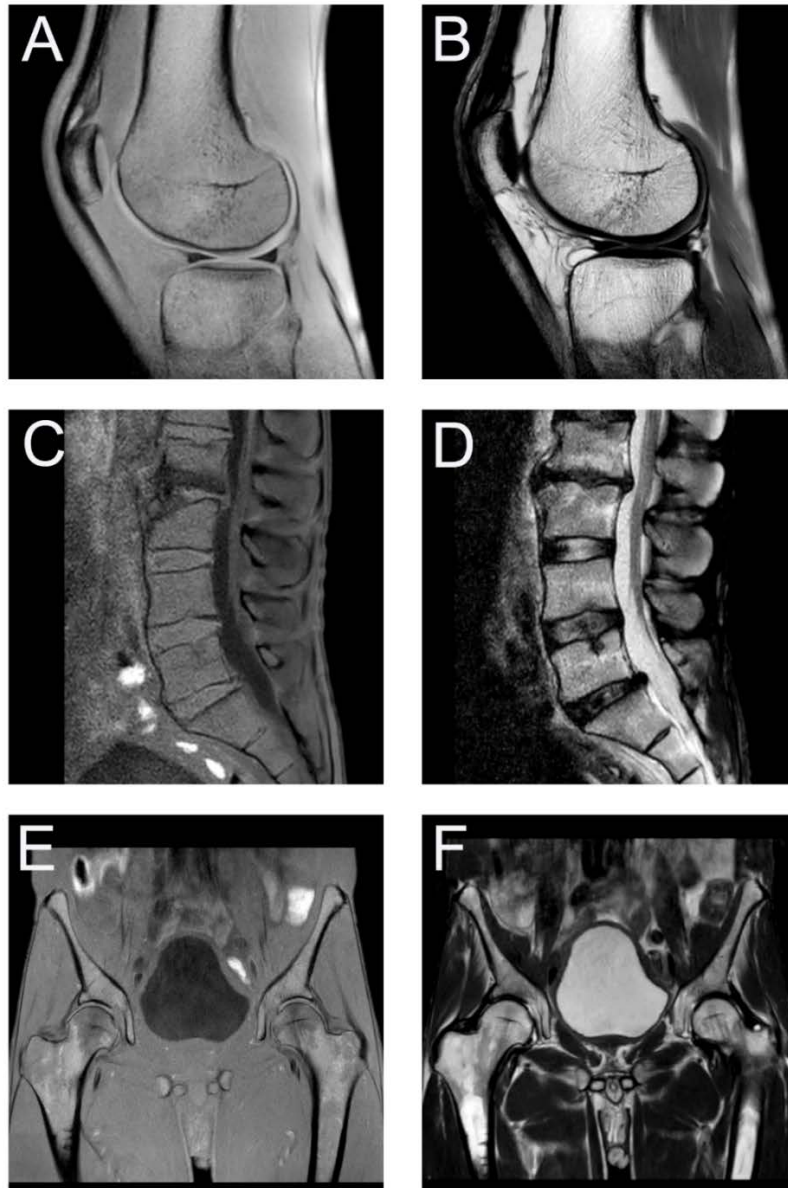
A) Sagittal T1 and B) Sagittal STIR images of the right knee was performed showing inversion of signal characteristics (the subcutaneous fat and bone marrow on the T1-weighted image are diffusely low signal and STIR images are diffusely high signal). This was repeated due to presumed technical error with same result. C) Sagittal T1-weighted and STIR image D) show similar result in the lumbar spine and showing minimal subcutaneous fat. E) Coronal T1-weighted and STIR image F) showing inversion of signal and very little subcutaneous fat.
